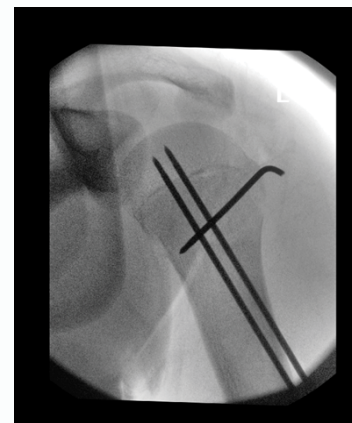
AP view x-ray of left shoulder post k-wiring.
